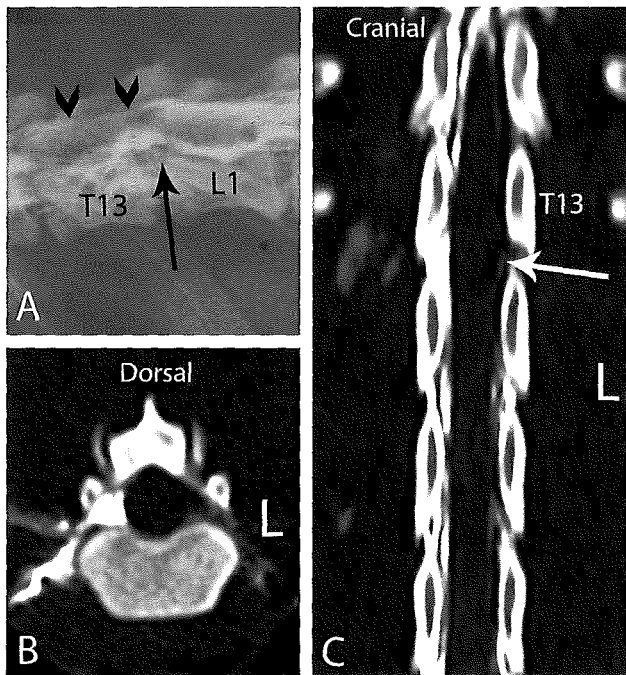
Computed tomography myelogram (kVp: 110, mA: 125, ms: 1500) of a 5-year-old intact male Staffordshire terrier with hindleg paresis. A) Transverse image at midbody of the 13th thoracic vertebrae (T13). B) Computed tomography at the T12-T13 intervertebral disc space showing a normal spinal cord and myelogram for comparison. C) Dorsal reconstruction of the thoracolumbar region.
